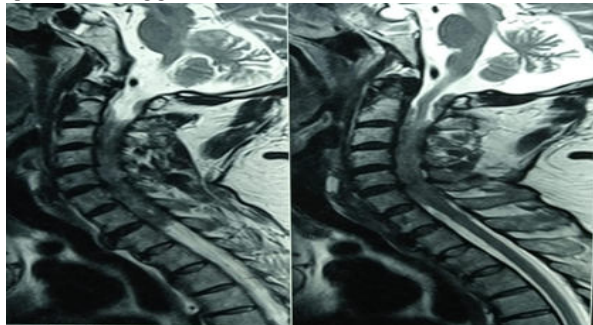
Pre-operative MRI images showing T2 hypointense cervical intradural lesion with cord compression.
